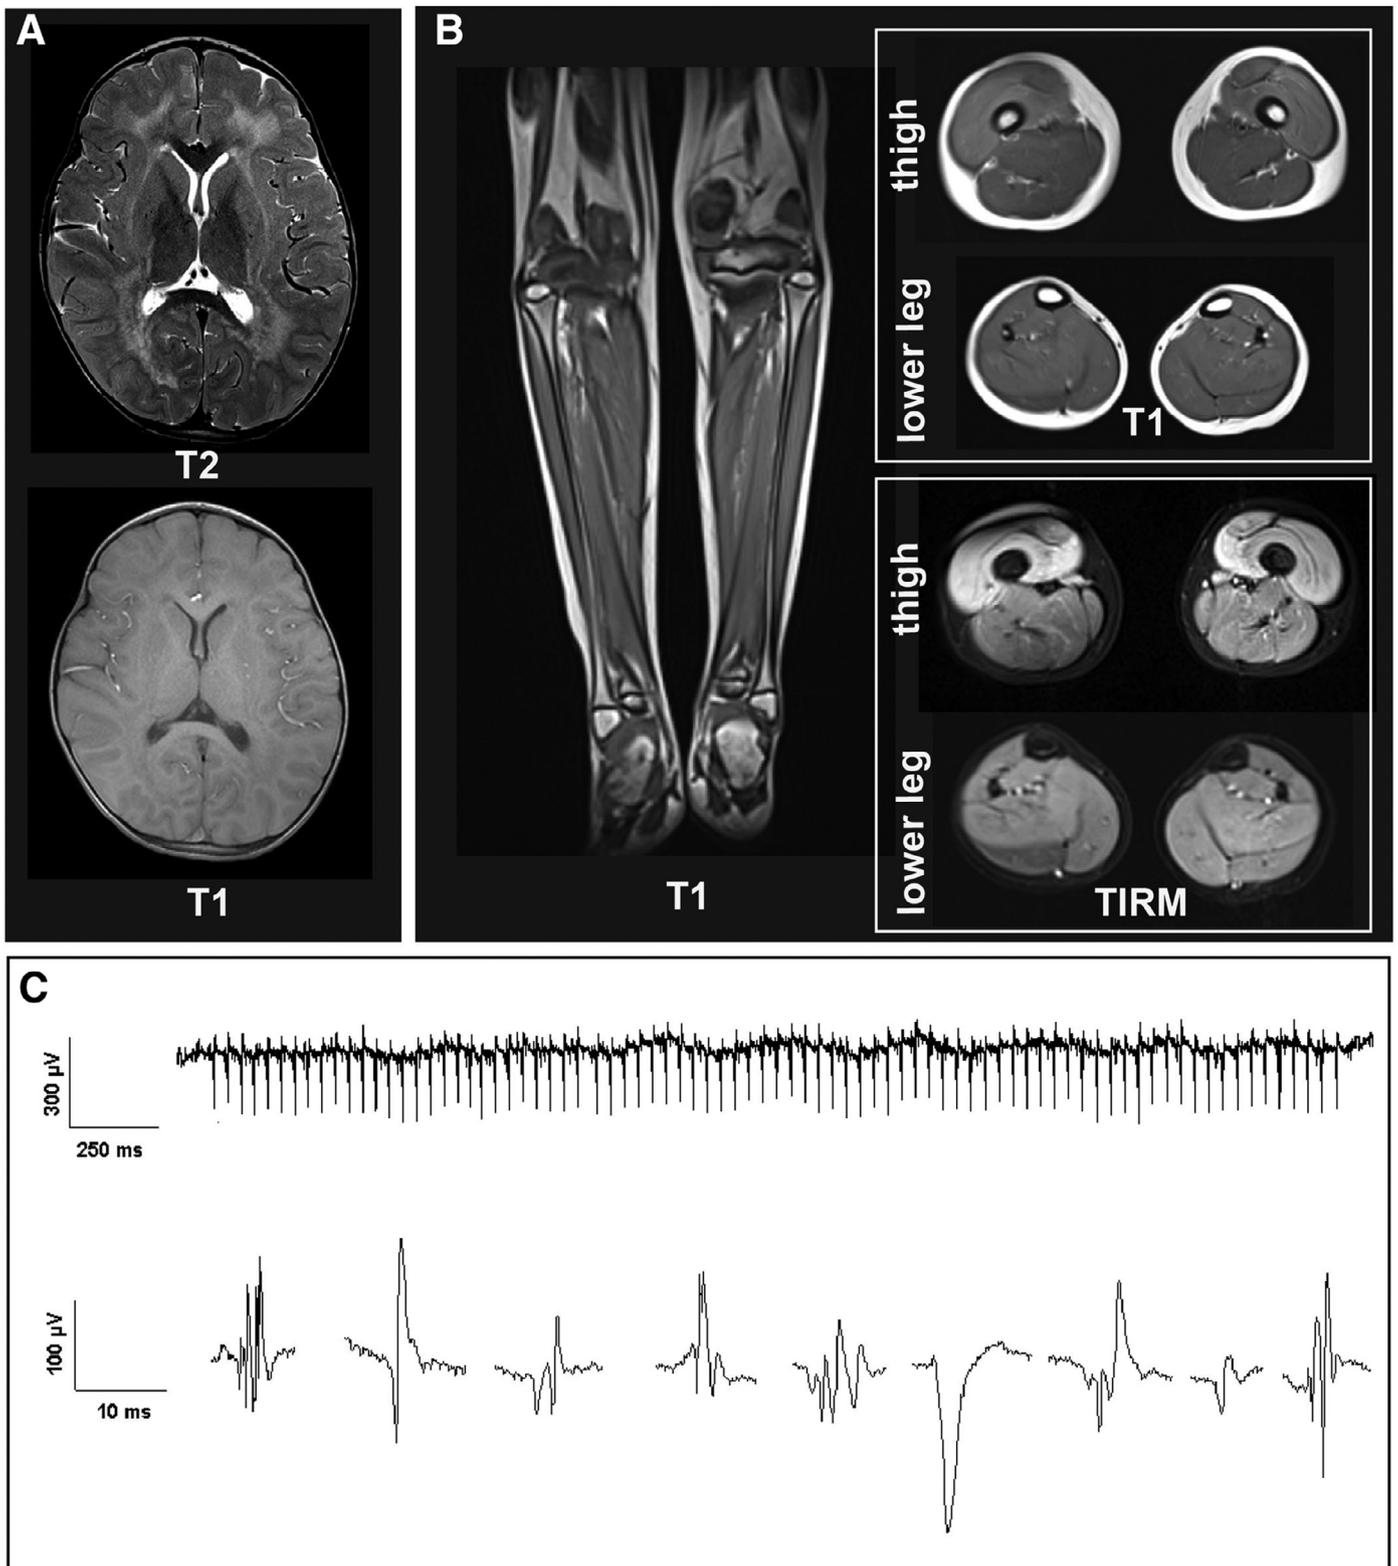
T1 and T2 weighted cranial MR image show a symmetrical and bilateral leukoencephalopathy with signal hyperintensities in T2 of the periventricular and deep white matter with apparent sparing of the U-fibers and involvement of the internal capsules (A). T1 weighted skeletal muscle MR images show preserved muscle bulks and no fatty degeneration, while Turbo-Inversion Recovery-Magnitude (TIRM) sequences disclose edematous alterations predominantly of the quadriceps muscles at the level of the thigh and of the lower leg muscles (B). Electromyography of the left anterior tibial muscle demonstrates marked complex-repetitive discharges lasting 5–25 s (upper line), as well as polyphasic motor unit potentials with short duration and low amplitude (lower line) (C).
